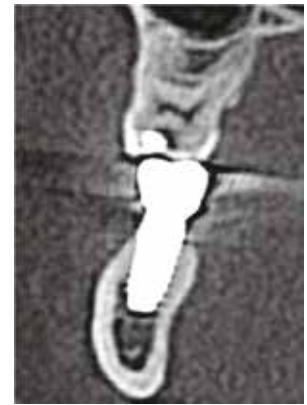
CBCT cross section after treatment with LMHFV shows bone level on buccal/lingual side of the implant and increase in density of the cancellous bone in contact with it.
